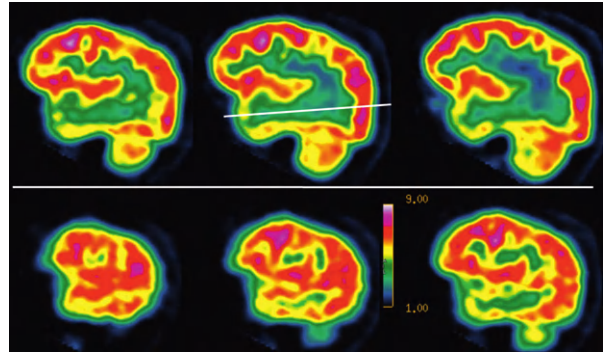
Intercictal [ $^{18}\text{F}$ ]FDG-PET scan in a patient with temporal lobe epilepsy, showing hypometabolism involving the left temporal lobe. The hypometabolism is more pronounced in the temporopolar region but involves the mesial part of the temporal lobe and extends to the lateral part (axial image in the hippocampal plane).
